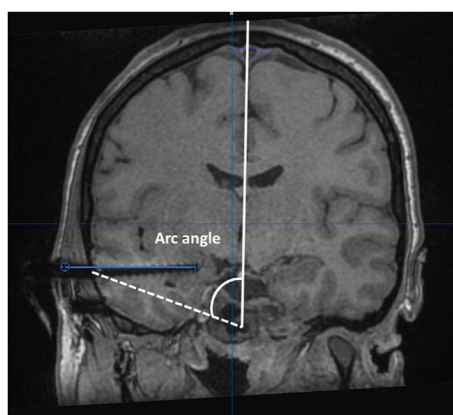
Definition of arc angle on a postoperative T1-weighted magnetic resonance imaging in the Brainlab software. The arc angle was defined as the angle between the vertex and the entry point. It was measured by calculating the angle between the midline and a line joining the entry point and the midline at skull base (white lines).
